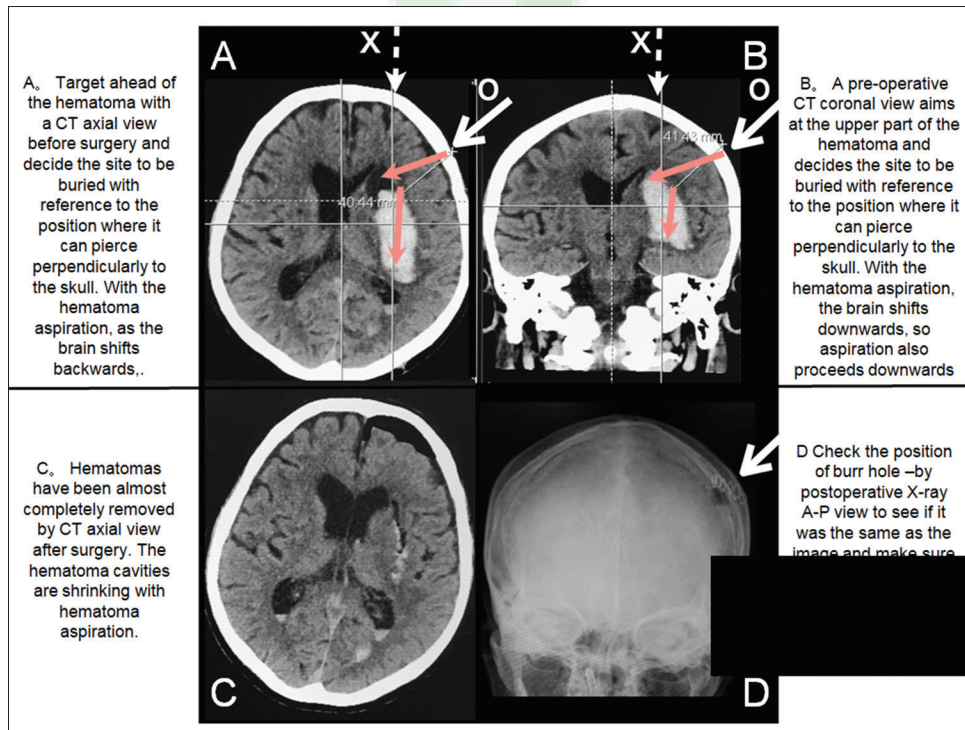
Computed tomography images - how to target
